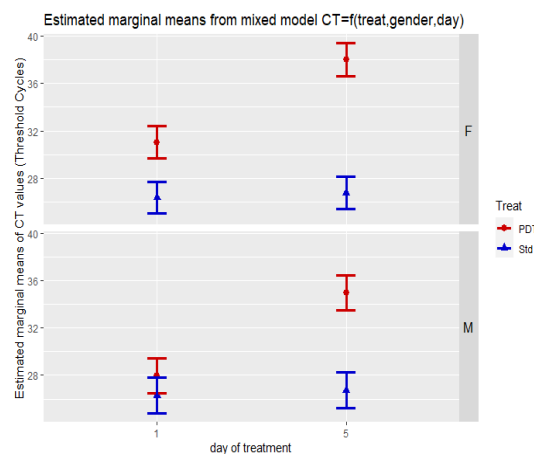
CT results based on 71 female and 61 male subjects. Note: Higher CT-values indicate a lower viral load; Std-standard therapy, PDT-photodynamic therapy.
